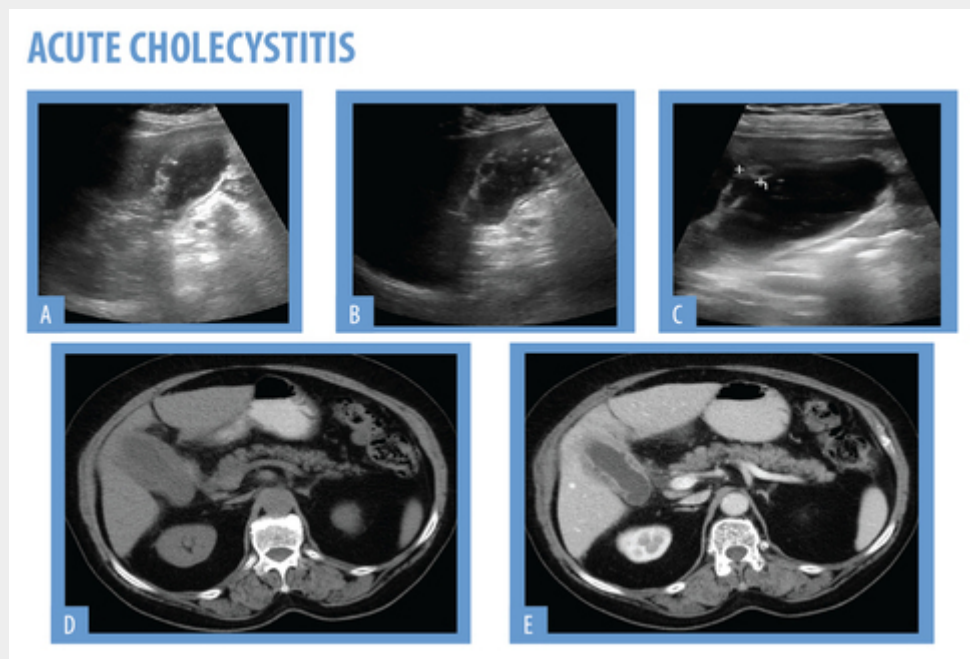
52 year-old patient presenting with RUQ pain. On US (A,B,C) the gallbladder is distended, with wall thickening, edema and stratification. CT images before intravenous contrast (E) and after (D) also demonstrate wall thickening and discrete pericholecystic fat stranding.
